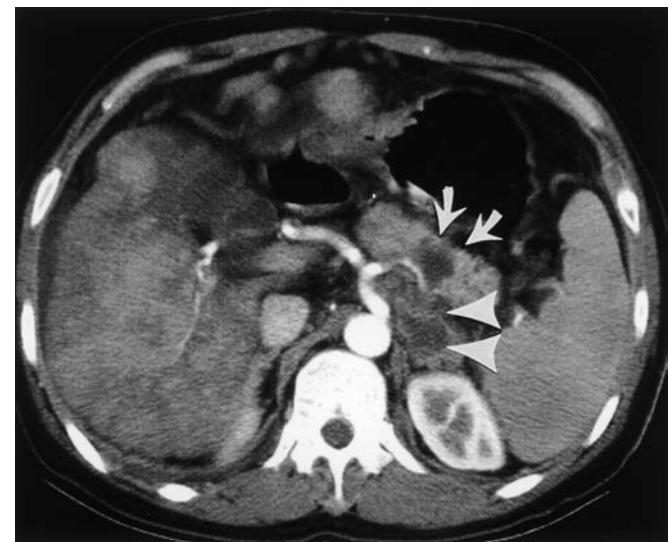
Pancreas metastasis. The CT scan shows an irregular mass (*arrows*) in the pancreatic tail and a hypoattenuating mass in the left adrenal gland (*arrowheads*)
